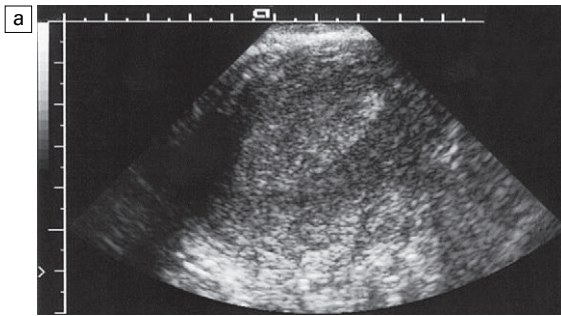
(a) Transvaginal ultrasound demonstrating endometrial hyperplasia. (b) Same patient. Colour flow Doppler demonstrating endometrial vascularity. (c) Spectral Doppler within the vessels in the endometrium shows resistance indices less than 0.77.
